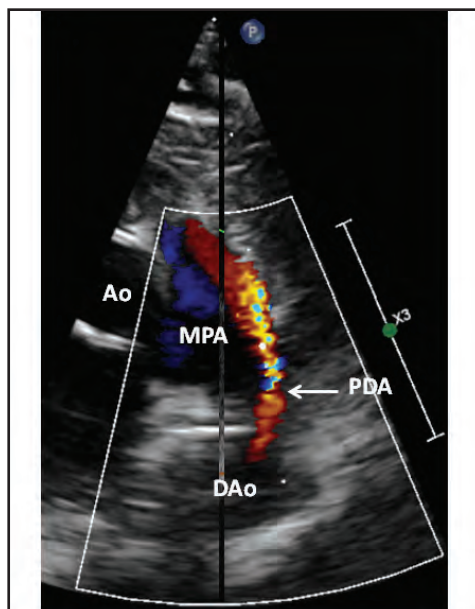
Selected video frame from precordial short axis view demonstrating a patent ductus arteriosus (PDA) with left to right shunt by color Doppler (arrow). Ao, aorta; DAo, descending aorta; MPA, main pulmonary artery.
